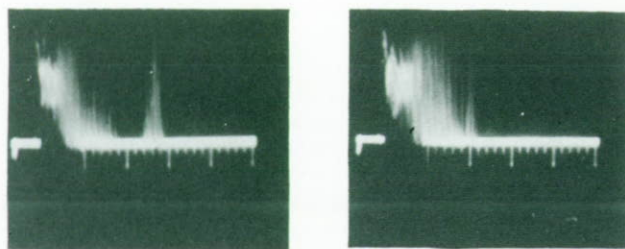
Ultrasound picture taken at the level of the normal diaphragm on (A) inspiration and (B) expiration. A relatively echo-free zone can be seen but the edge of this space is not clear cut.
